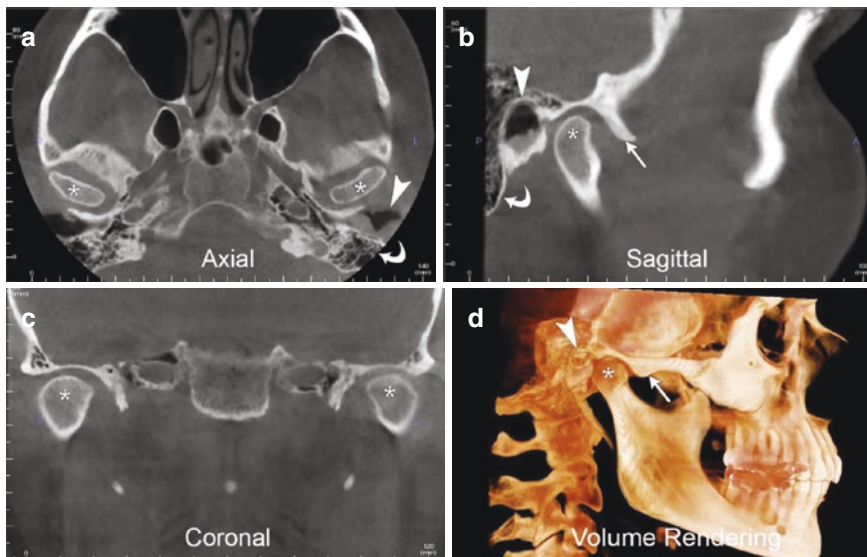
CBCT standard display includes axial, sagittal, and coronal views along with volume rendering. These views demonstrate normal anatomy in all three planes: mandibular condyles (*asterisk*), external auditory canal (*white arrowhead*), articular eminence (*straight arrow*), and mastoid air cells (*curved arrow*)
